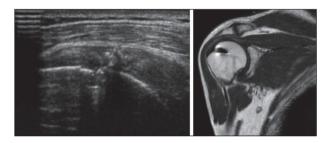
Ultrasound evaluation at 6 months and MRI evaluation at 24 months for patient treated with screw fixation (group A)
